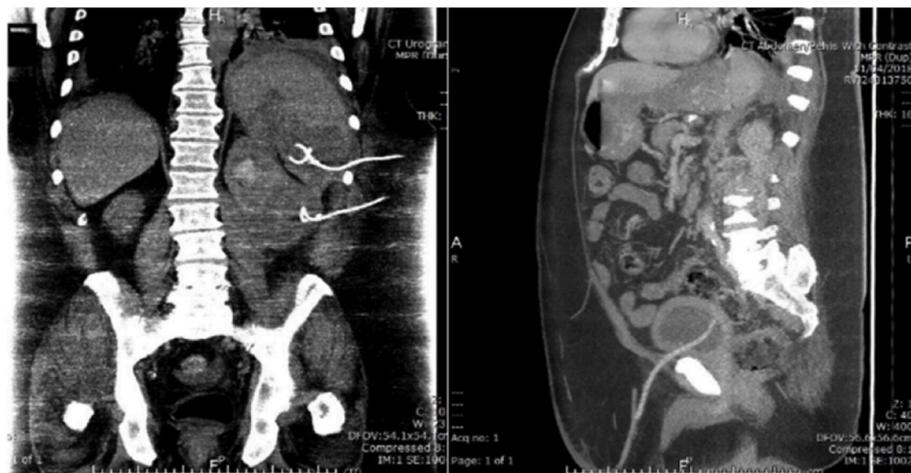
CT images following insertion of left nephrostomy, splenic drain and suprapubic catheter.
